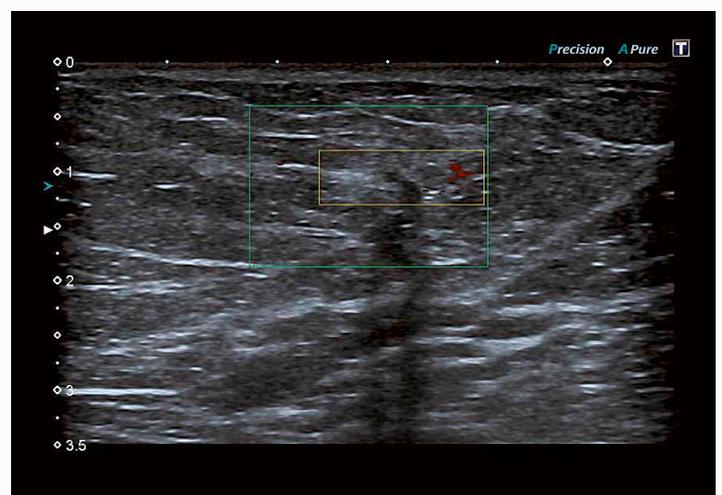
Power Doppler shows strong vessels adjacent to the tumor, the vascularization index at 5.7% of the entire area is rather low. Nevertheless the branching-off of the strong vessel is typical for a tumor feeder vessel.
